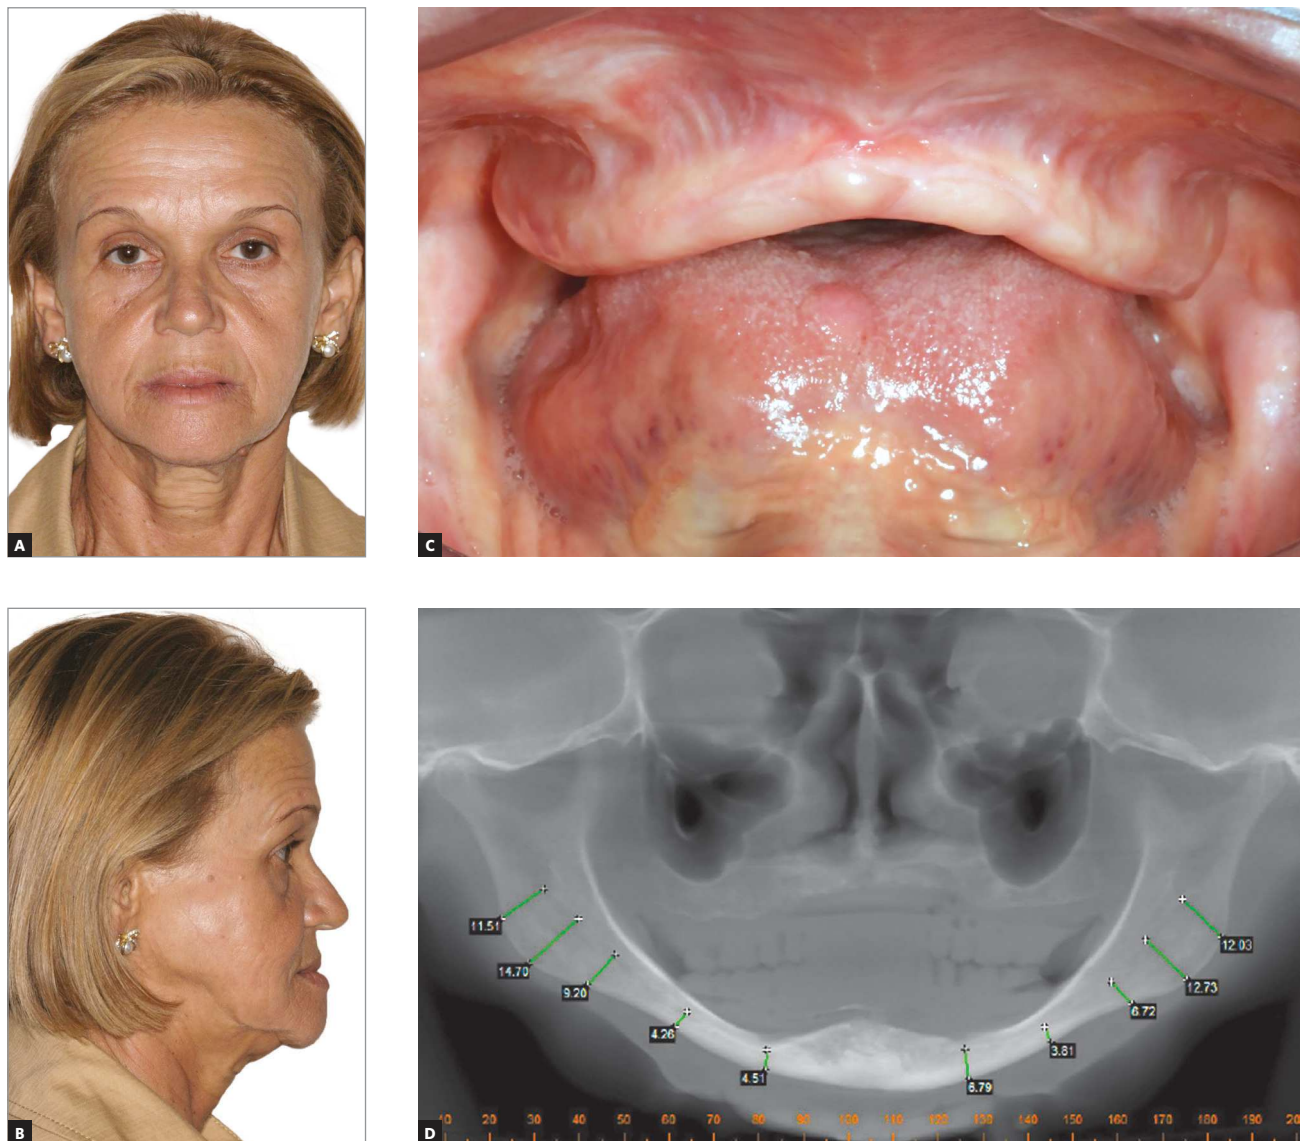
Preoperative images: A) frontal view at rest; B) lateral view at rest; C) alveolar ridge preoperatively; D) cone-beam computed tomography evidencing the atrophic alveolar ridges.
